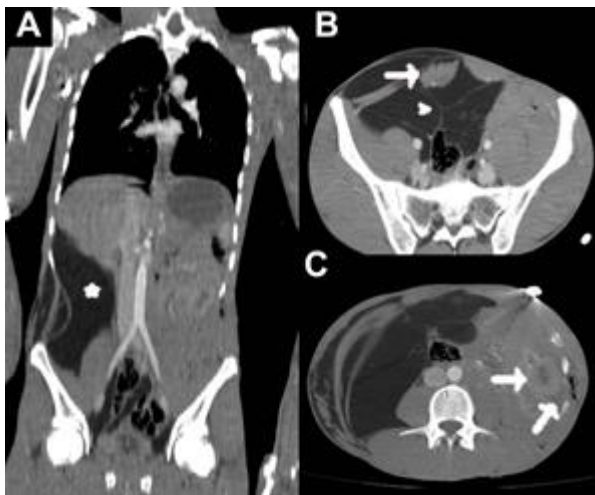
Coronal CT image (A) shows a fat density mass on the right side (asterisk) with all intestinal and colonic loops are seen on the left of abdomen. Axial image from pelvic level (B) shows right sided atrophy of the abdominal wall muscles (arrow) and septa within the lipoid mass (arrowhead). At the level of stab wound, axial image (C) shows increased wall thickness of the intestinal loops along with peri-intestinal fluid collection (arrows).
